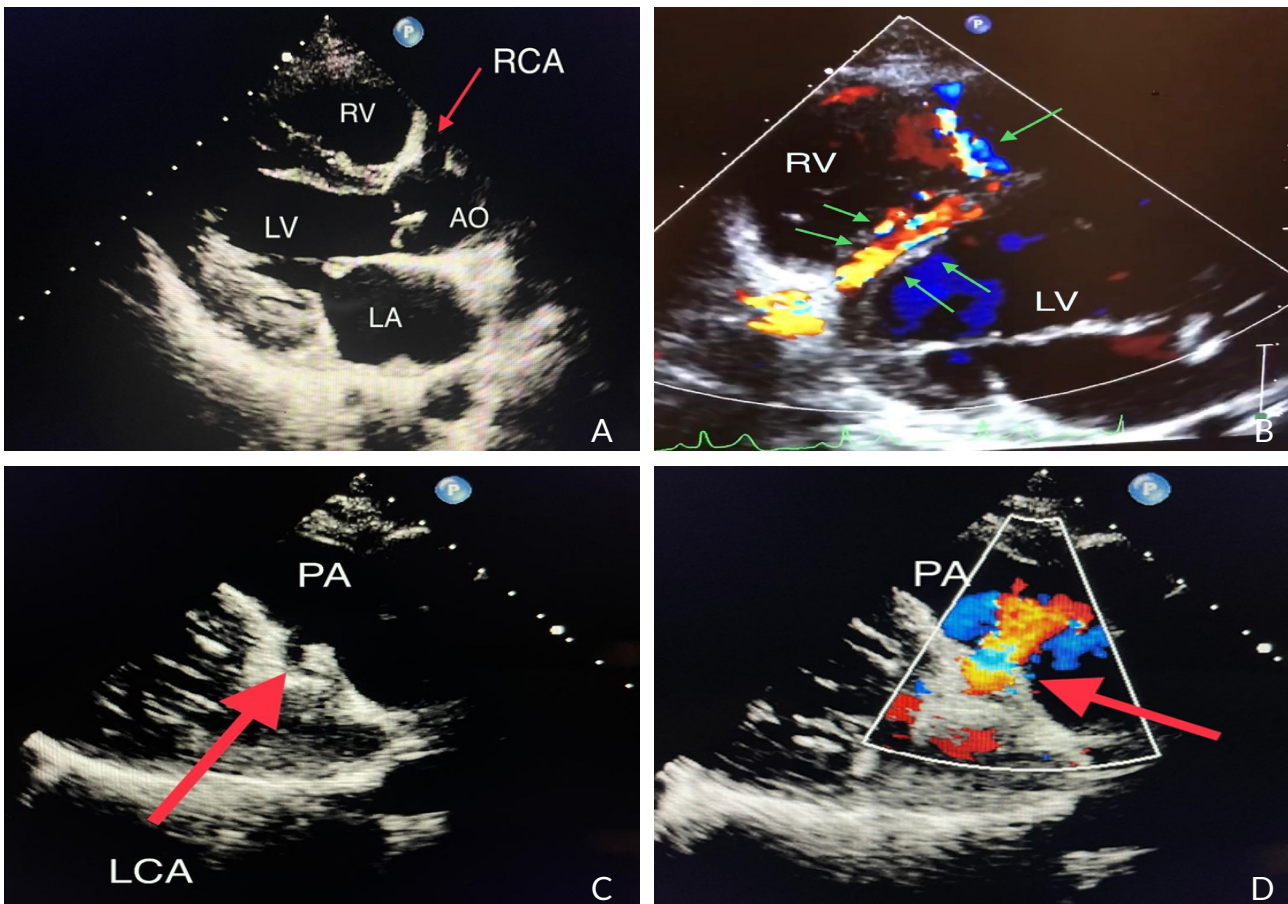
(A) The parasternal long-axis view. The dilated right coronary artery (RCA) is clearly visible. (B) The parasternal short-axis view. The green arrows demonstrate the increased flow in the intraventricular collateral vessels from the RCA to the LCA. (C) The parasternal right ventricle outflow view shows the take-off of the anomalous left coronary artery (red arrow) from the pulmonary artery. (D) Retrograde blood flow to the pulmonary artery from LCA (red arrow). AO: aorta, LA: left atrium, LV: left ventricle, RV: right ventricle, PA: pulmonary artery, LCA: left coronary artery.
